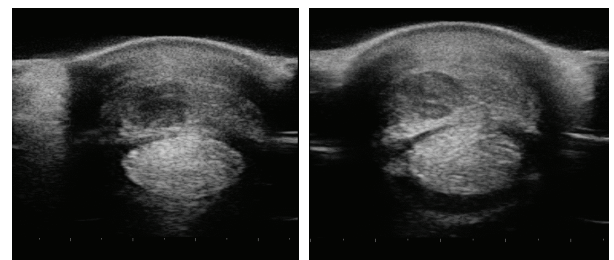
Ultrasound scans of the FRL (acute lesion)
